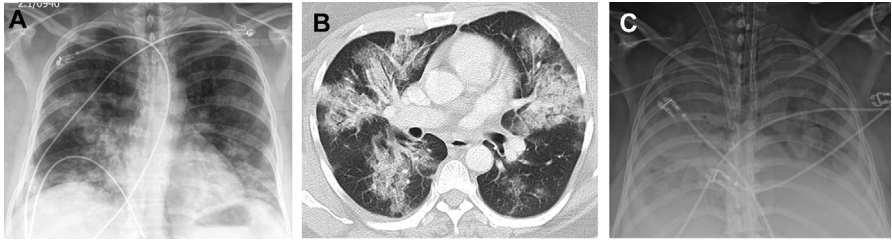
Forty-three-year-old otherwise healthy woman with H1N1 infection demonstrating progression from bronchopneumonia to ARDS. (A) Initial frontal chest radiograph demonstrates bilateral hazy perihilar and basilar airspace opacities. (B) Axial chest CT on the same day shows bilateral peribronchovascular ground-glass opacities, with areas of interlobular septal thickening. (C) Frontal chest radiograph 11 days later shows near-complete opacification of both lungs and an extracorporeal membrane oxygenation (ECMO) catheter.
